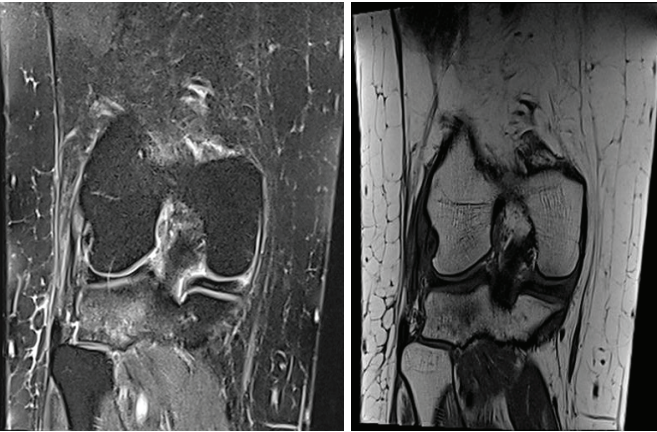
(LCL Tear): PD Cor & T1 Cor MR image in a 30-year-old male football player shows a partial tear in the upper part of LCL and marrow edema in the lateral tibial plateau.
